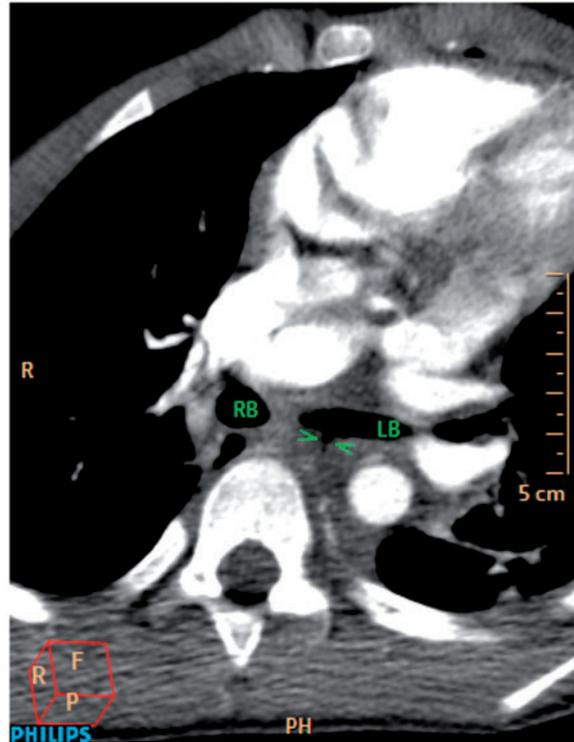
CT scan of the chest showing an indentation in the left main bronchus suspected to be an incomplete rupture.
